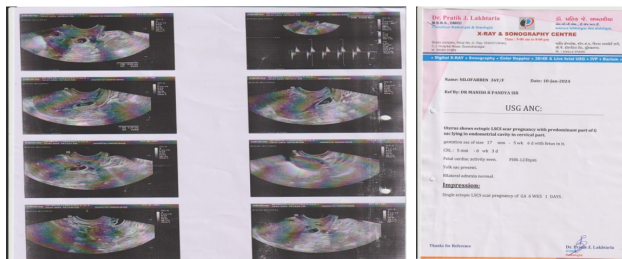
Transvaginal sonography performed on January 10, 2024 (A, B and C)
